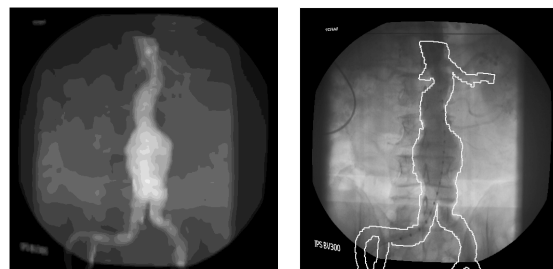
Overlay of aorta with aneurysm (segmented from pre-operative CT images) onto intra-operative X-ray image
